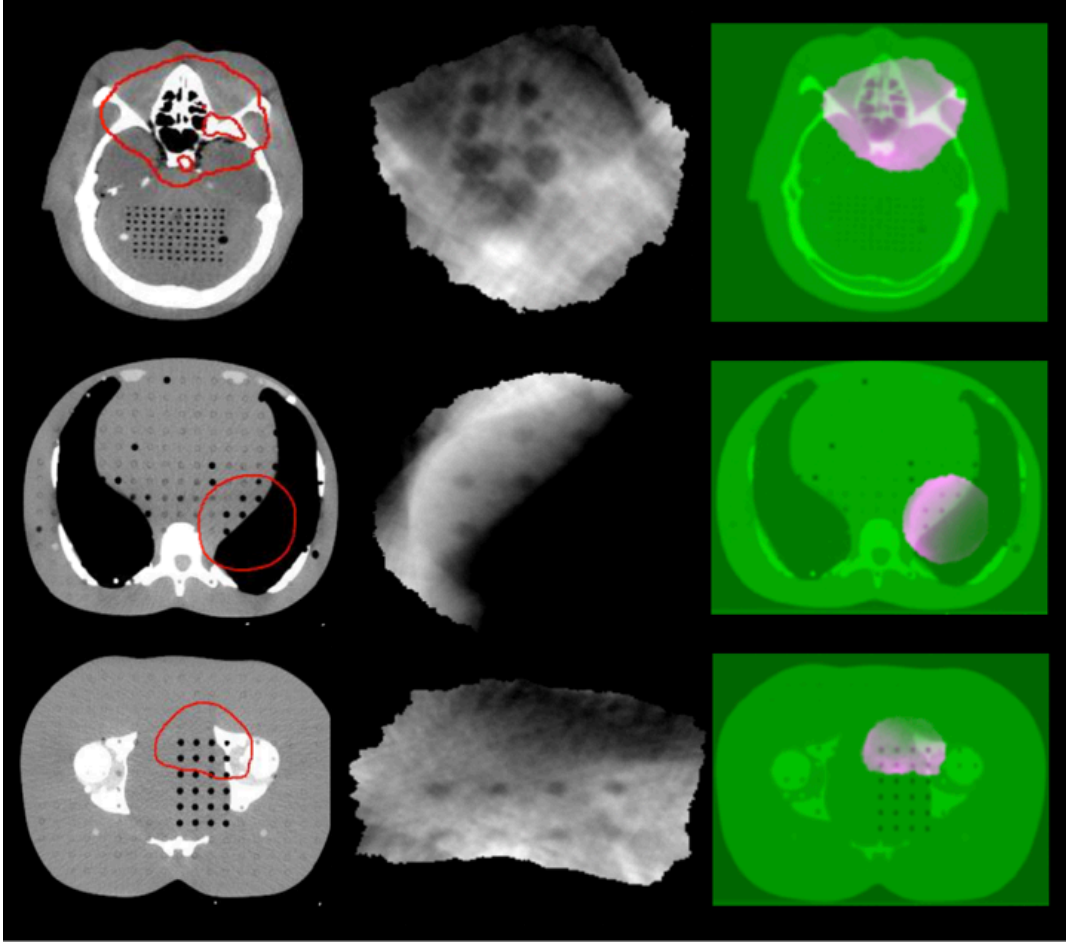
Axial view of planning CT images overlaid by the red prescription isodose lines (first column), reconstructed VMAT-CT images (second column), and VMAT-CT+ image sets containing registered VMAT-CT (pink) and planning CT (Green *et al.*) (third column) for a head plan (top row), an abdomen plan (middle row), and a prostate plan (bottom row).
